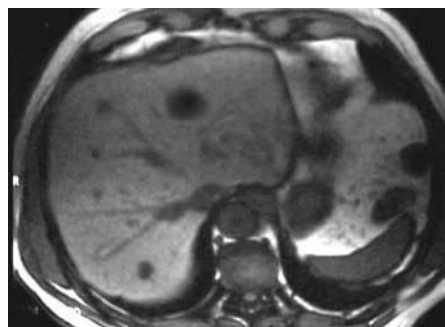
Depending on the system used, from 12 to more than 30 T1-weighted GRE images, similar to this FLASH (TR 150, TE 2.5), can be obtained in a breath-hold. This is sufficient to image the entire liver using 6-10 mm single slices in 15-30 seconds.
